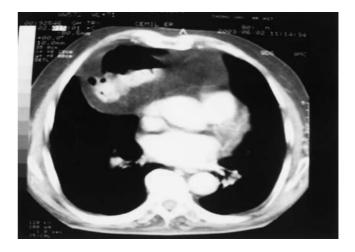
Computed tomography image of a patient with Morgagni hernia containing omental fat and the colon
